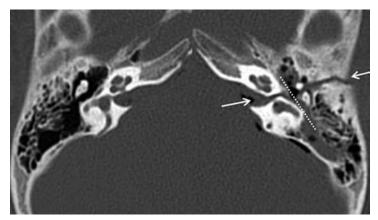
Head injury with hemotympanum. Axial unenhanced CT image through the left temporal bone demonstrates a transverse fracture (arrows) with ossicular dislocation (note separation of the malleus and incus on the left in comparison with the right "ice cream scoop separated from cone"); fracture traverses through the expected tympanic course of the facial nerve (dotted line) and through the internal auditory canal/inner ear. Associated opacification of the left middle ear and mastoid and pneumocephalus are also seen.
